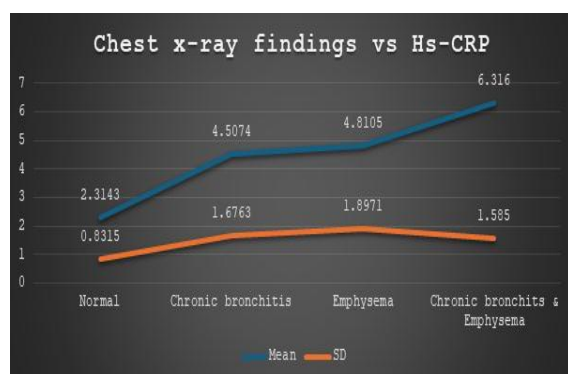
Chest x-ray findings and Hs-CRP
